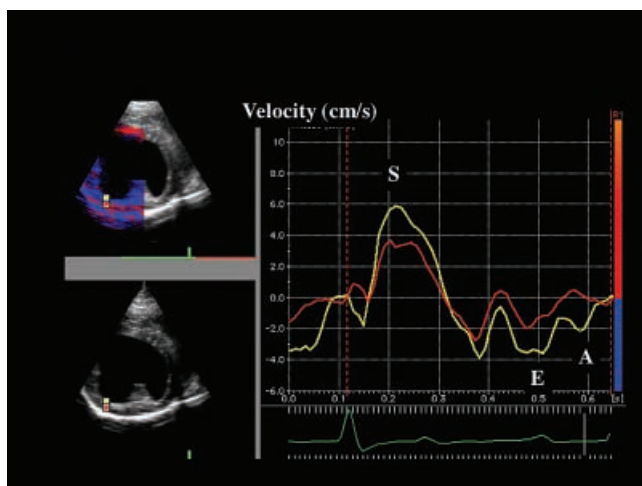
Analysis of the left ventricular segmental radial motion using two-dimensional (2-D) colour Tissue Doppler Imaging (TDI) mode recorded from the right parasternal short-axis view. The simultaneous recording of the velocities in the two segments (endocardial and epicardial) shows that the endocardial layer (yellow curve) is moving with good synchrony more rapidly than the epicardial layer (red curve) during the whole cardiac cycle. The normal systolic radial myocardial velocities exclude a systolic dysfunction.
